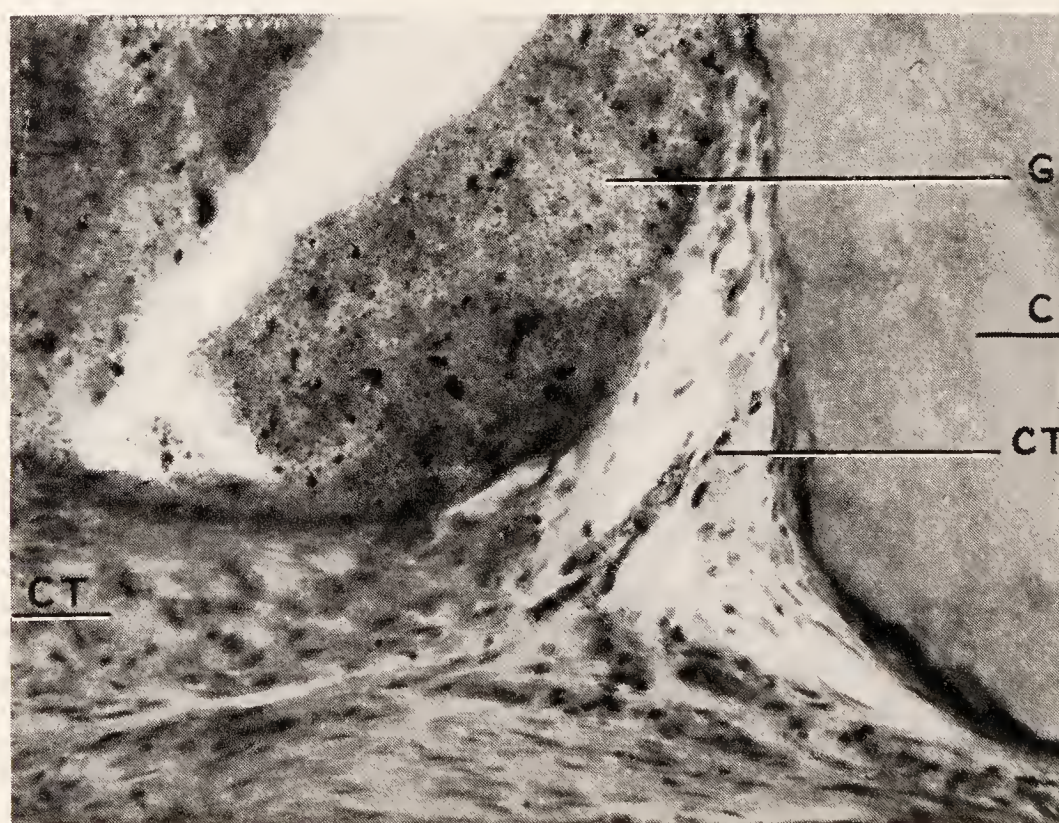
High magnification of Fig. 166. G, guttapercha; C, cementum; CT, fibrous connective tissue of periodontal membrane lying in direct contact with guttapercha and wall of root canal. Notice the absence of any inflammatory reaction in the periapical connective tissue. (Courtesy of E. D. Coolidge.)
